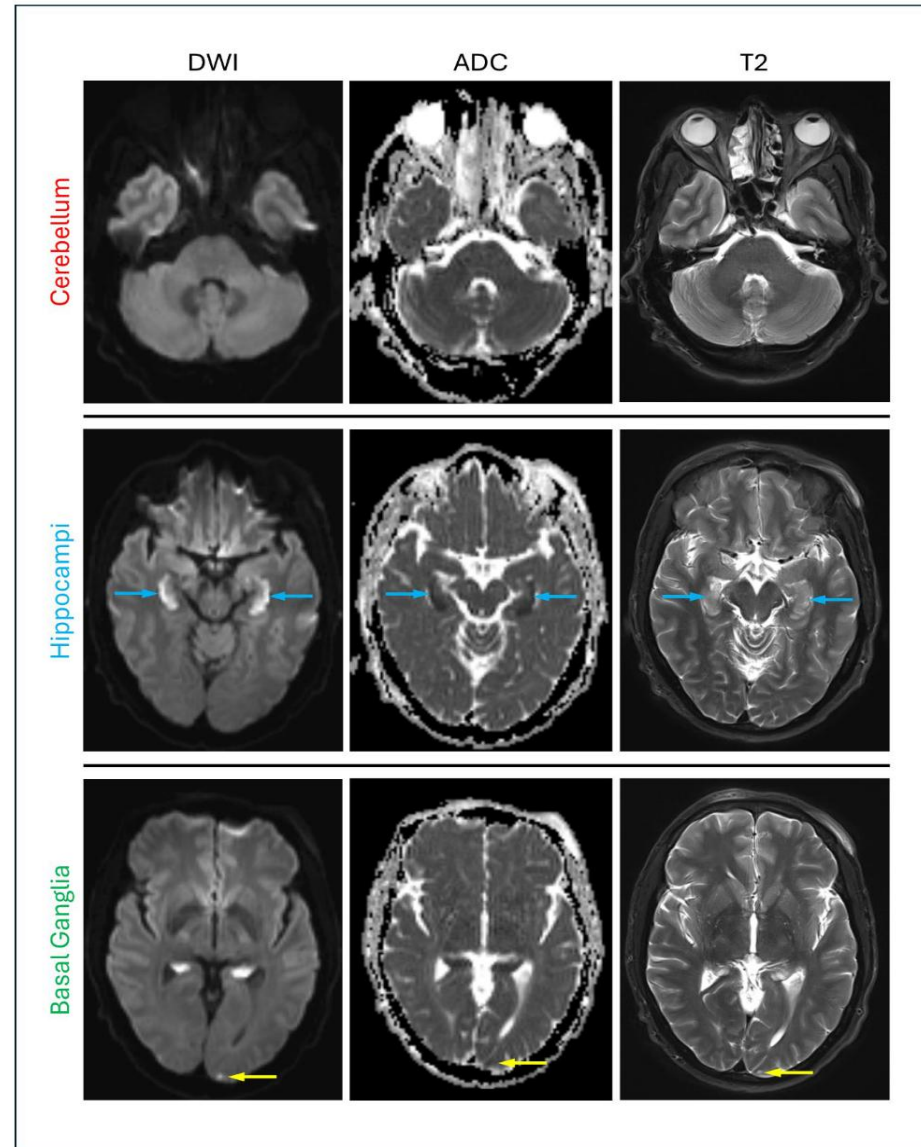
MRI case example of CHANTER syndrome in a 52-year-old male patient with representative DWI, ADC, and T2 axial images. Areas of restricted diffusion and T2 signal hyperintensity are demonstrated in the hippocampi (blue arrows). In addition, there are areas of similar signal abnormality involving the posterior left cerebral cortex (yellow arrows).
